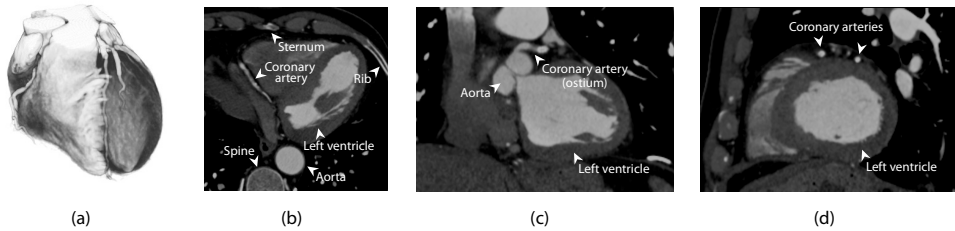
A computed tomography angiography scan of the coronary arteries. (a) Volume rendering, (b) Transversal view, (c) Coronal view, (d) Sagittal view.
